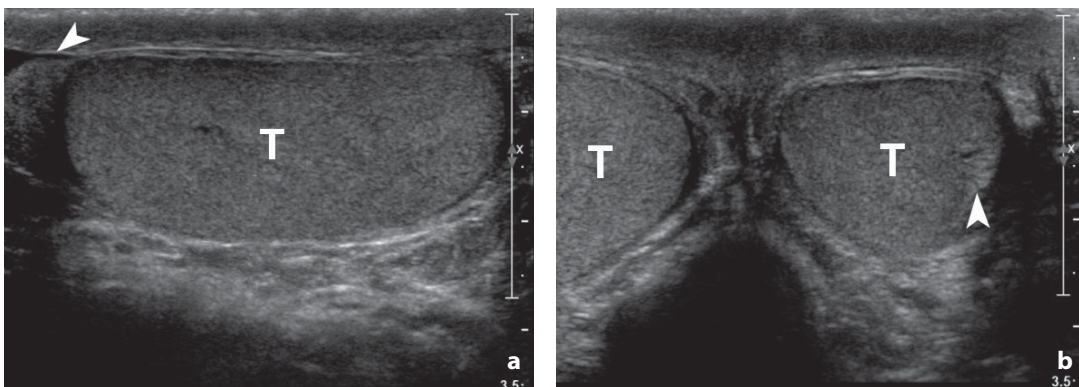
Normal anatomy. Ultrasonography of the normal testicle (T). a Sagittal scan. b Axial scan. The testicle shows uniform echotexture, with small echoes of mid-high intensity. a The head of the epididymis is visible cranially to the testicle (arrowhead). b The mediastinum testis can be visualized as a mildly hyperechoic image roughly triangular in shape at the periphery of the testis (arrowhead)
